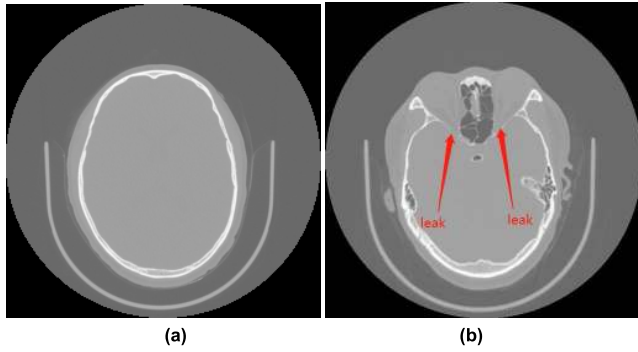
Different part of brain of CT images: (a) the upper part of brain tissue, (b) the lower part of brain tissue.
